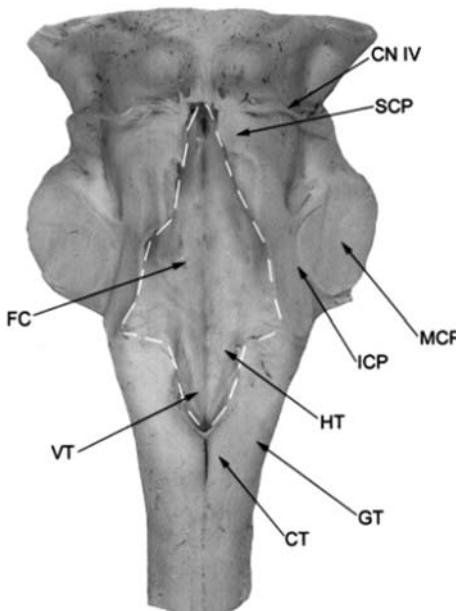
Posterior surface of the brain stem. The rhomboid fossa (outlined by dashed lines), visible after removal of the cerebellum, forms the floor of the fourth ventricle. The facial colliculus (FC), hypoglossal trigone (HT), and vagal trigone (VT), formed by underlying cranial nerve nuclei, are slight elevations located on the floor of the rhomboid fossa. The cuneate tubercle (CT) and gracile tubercle (GT) are located caudal to the rhomboid fossa and are formed by underlying sensory nuclei. Rostral to the rhomboid fossa, cranial nerve IV (trochlear) is seen originating from the posterior surface of the brain stem. The inferior cerebellar peduncle (ICP), middle cerebellar peduncle (MCP), and superior cerebellar peduncle (SCP), which connect the brain stem to the cerebellum, are visible.
